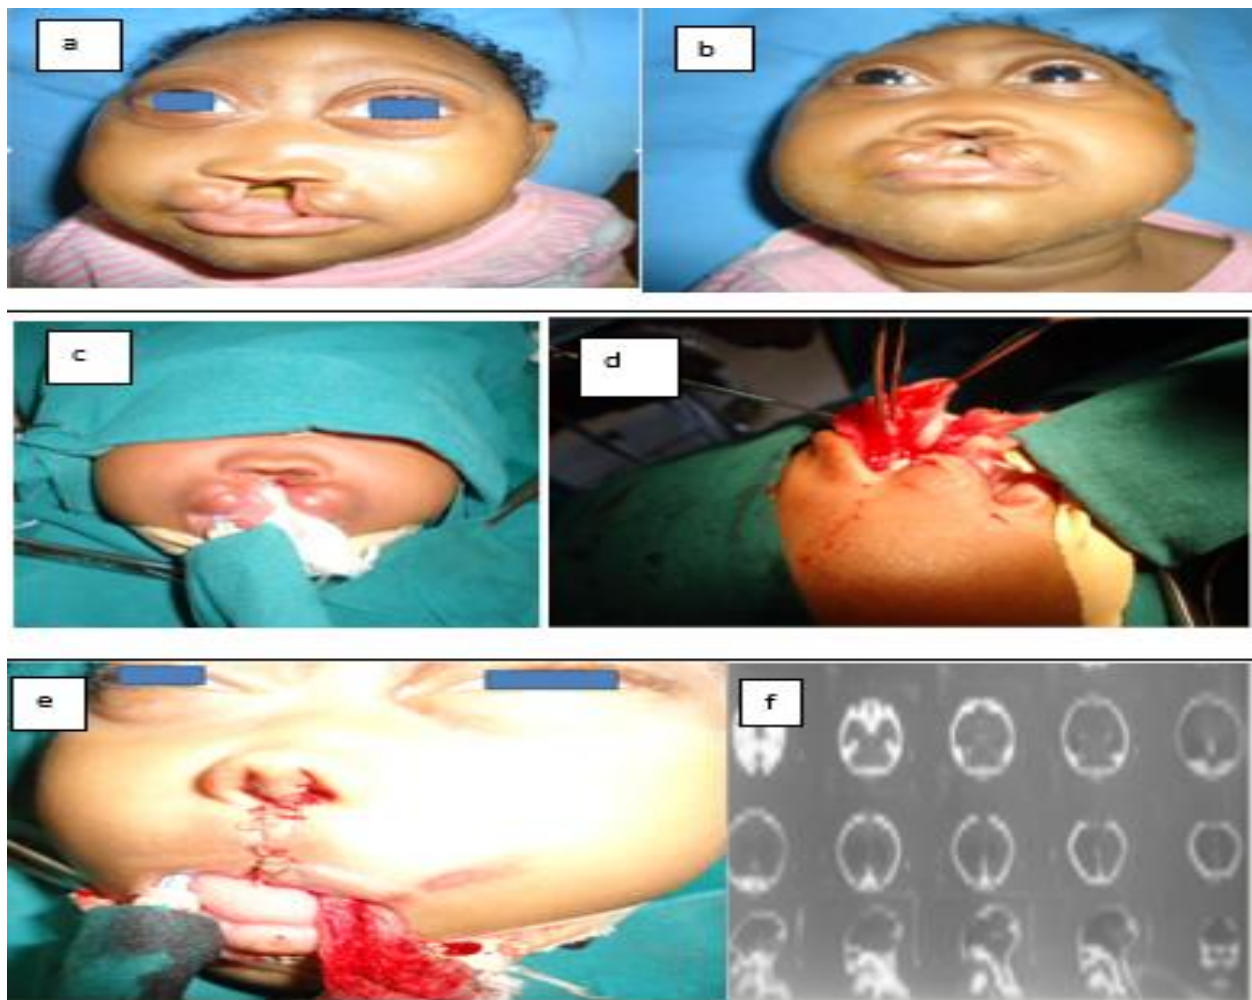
Legend- a and b are preoperative pictures showing the false median cleft, c and d are intra-operative pictures. e. Immediate post-operative picture. f is CT scan images of the patient
